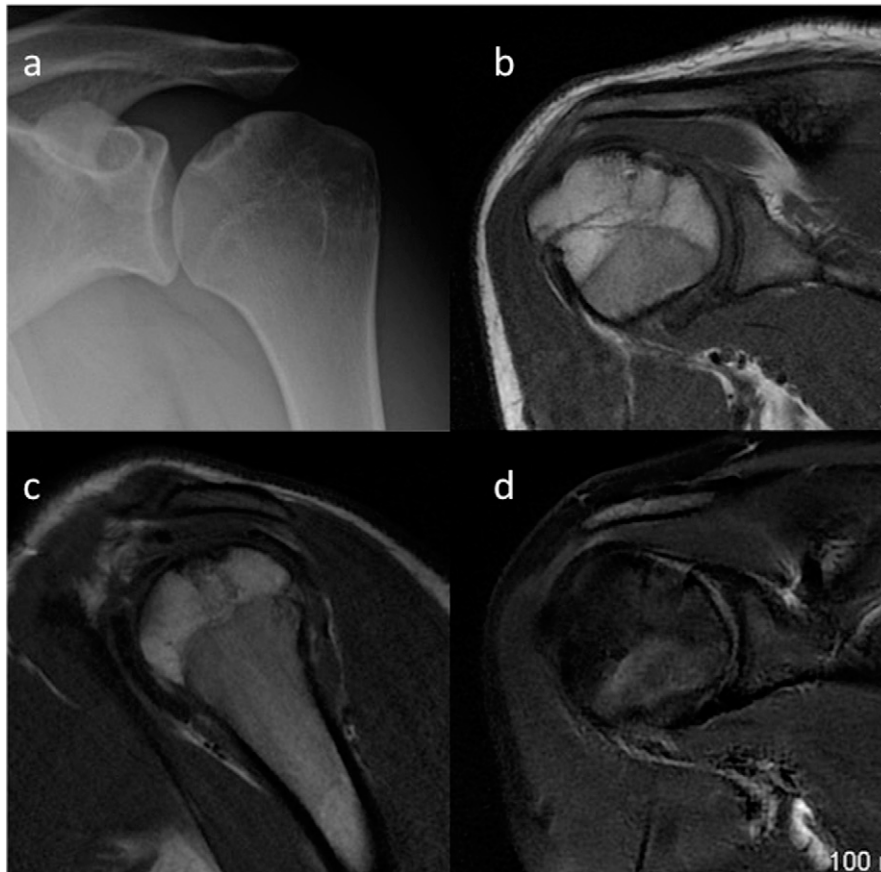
Anteroposterior radiograph (Fig. 3 A) and MRI scans (Figs. 3 B [T1 weighted], 3 C [T1 weighted], and 3 D [fat saturated T2 weighted]) at the 26 month follow up showing the integrated graft and a level joint surface.
